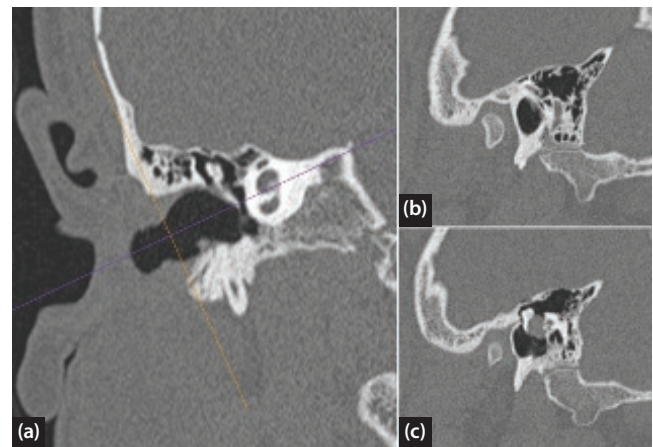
Reconstruction of CT scan images along plane of external auditory meatus, best used for pre-operative planning in endoscopic ear surgery.
